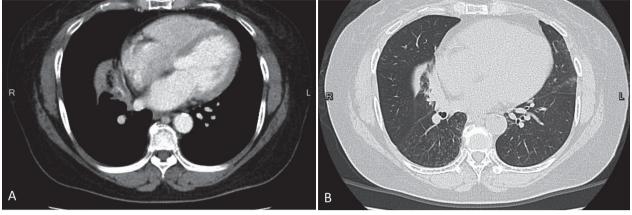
Follow-up CT, 8 months after initial presentation. (A) Contrast CT. (B) High-resolution CT.
